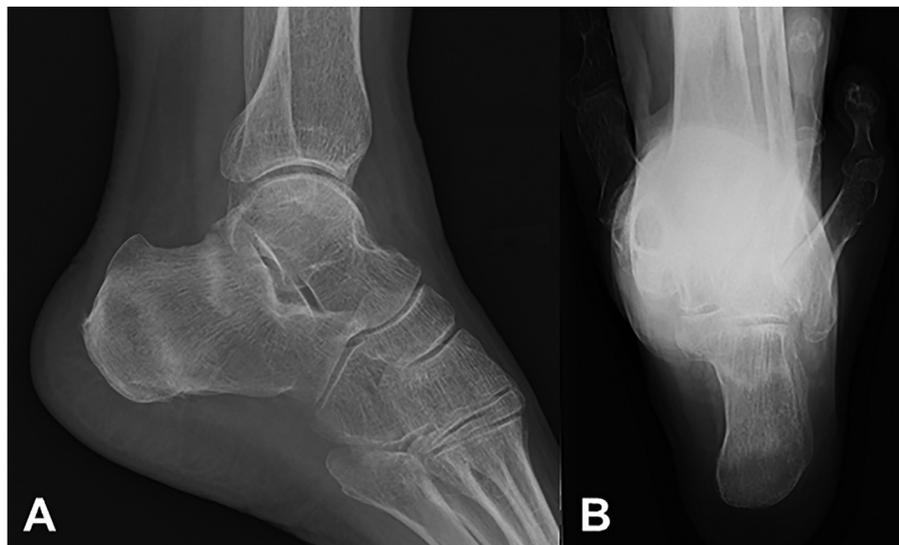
Multiple calcaneal insufficiency fractures. (A) Lateral and (B) axial plain radiographs. A type 1 fracture with a radio-opaque irregular line occurred after bone union of the type 2 fracture with a sclerotic line.
